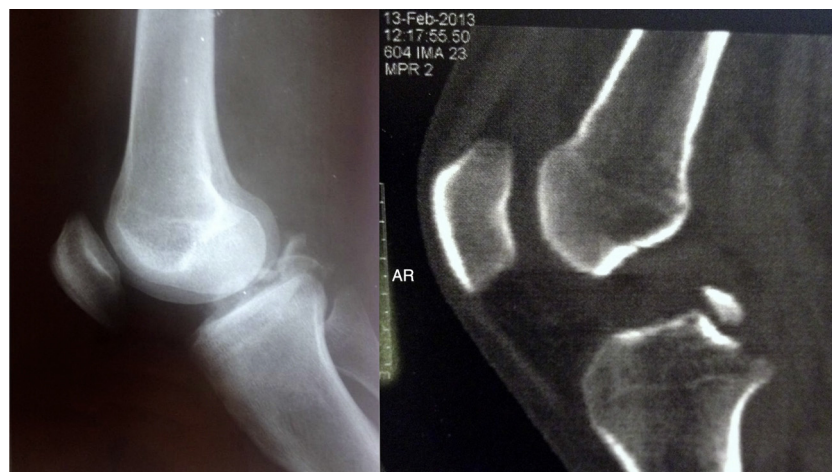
Simple radiography and computed tomography before the operation.
